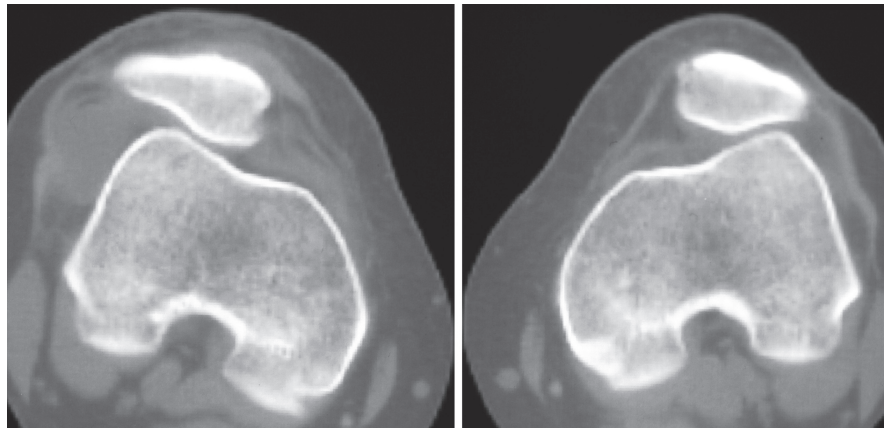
Computed tomography (CT) examination in 0° extension and quadriceps contraction shows lateralization of the patella (Reprinted from Sanchis-Alfonso et al.²³, with permission from Elsevier)
